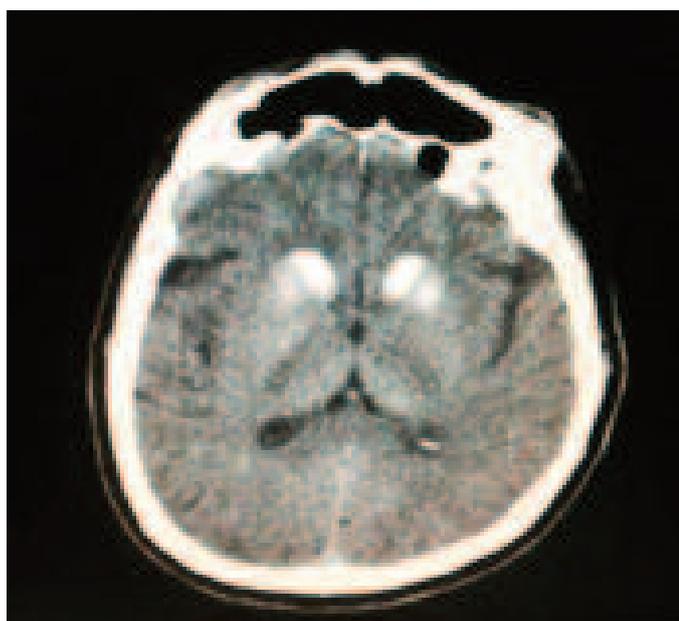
Brain CT scans of patient 3, showing massive calcifications of the bilateral basal ganglia, the periventricular white matter of the thalamus, the centrum semiovale, the posterior fossa and the bilateral cerebellar hemispheres.
